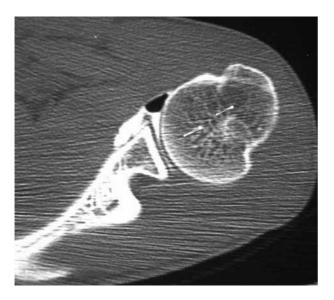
Preoperative double contrast CT arthrogram of right shoulder joint shows anterior labral defect and small Hill-Sachs lesion.
